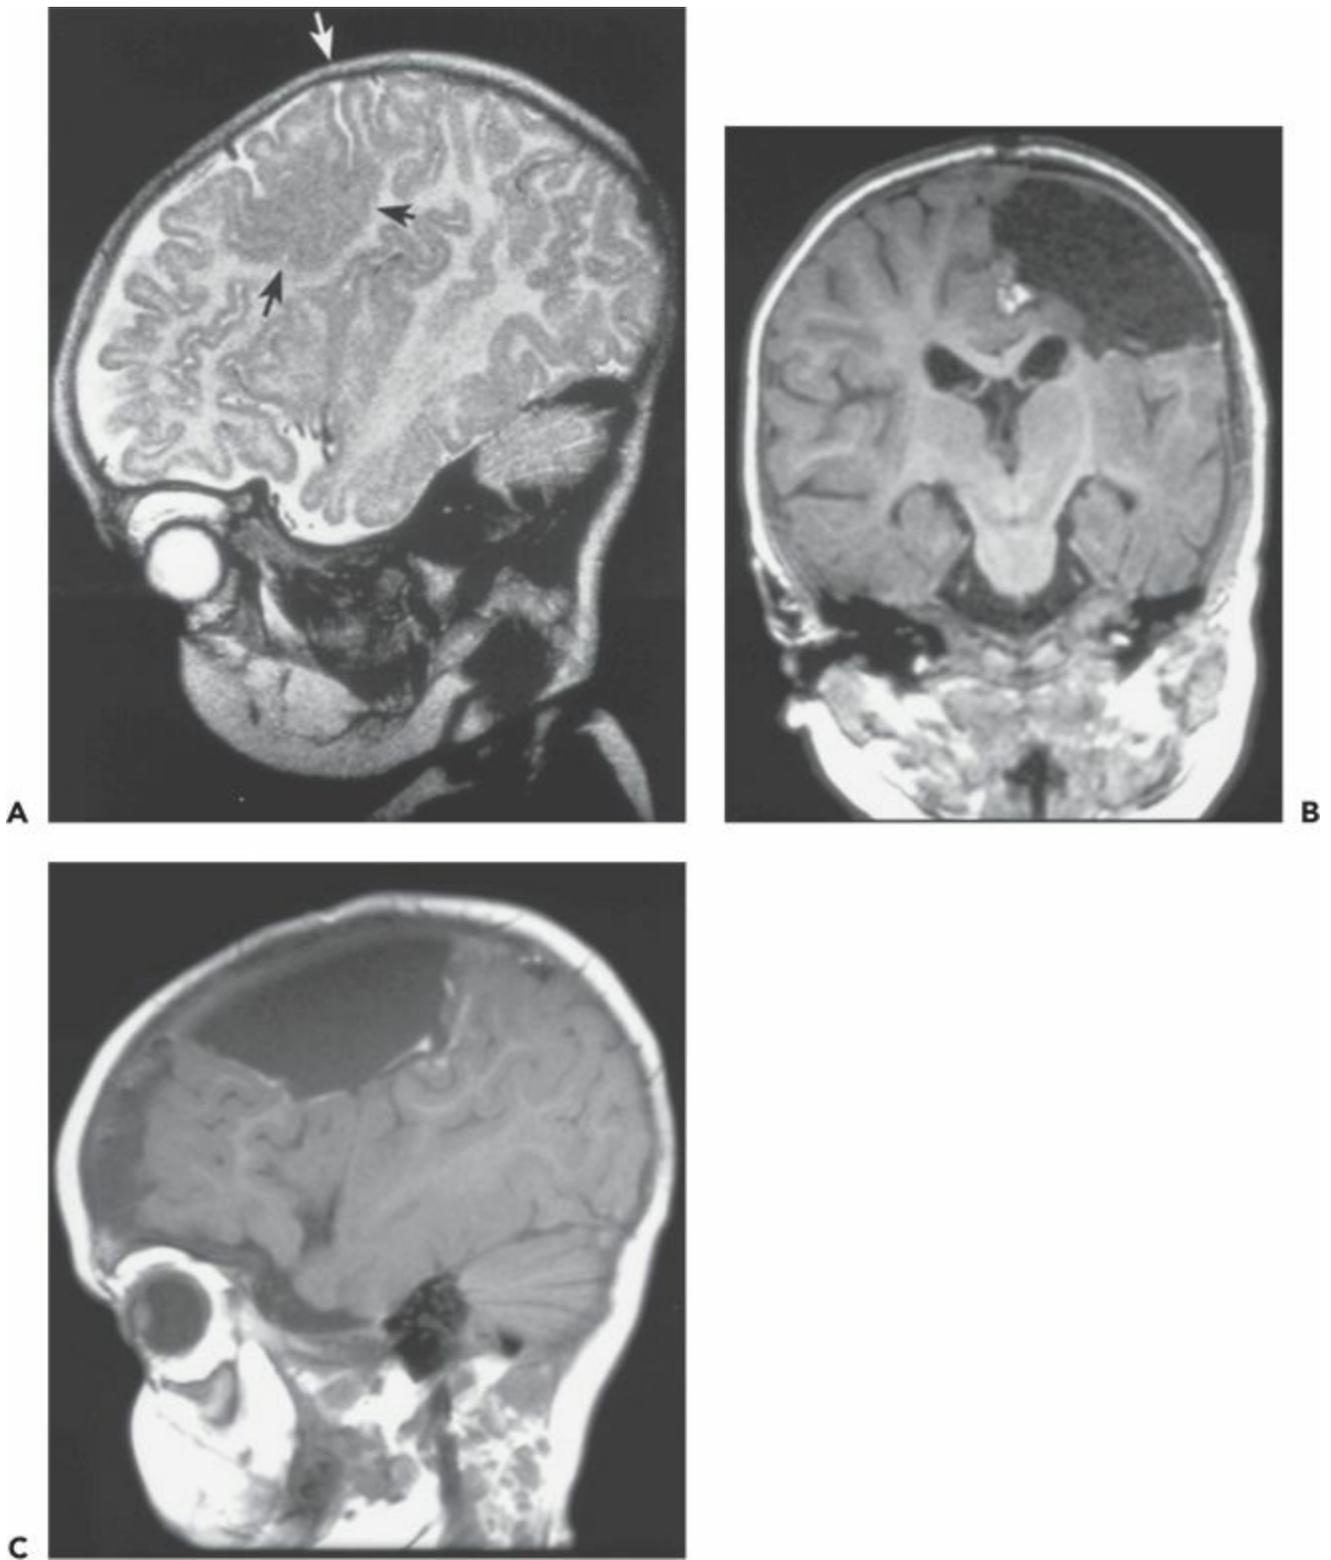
Case 2. A: Sagittal magnetic resonance image showing focal malformation of cortical development cerebral dysgenesis (black arrows) in the left posterior frontal lobe extending across the central sulcus (white arrow) into the anterior portion of the postcentral gyrus. The boy was 4 months old at the time of the MRI, with intractable daily seizures since the first day of life after an uncomplicated full-term delivery. Seizures involved clonic jerking of the right arm and leg, with eye deviation toward the left, or opisthotonic posturing with stiffening and extension of all extremities. Ictal and interictal epileptiform discharges were localized to the left central region. Moderately severe right hemiparesis and mild developmental delay were also present. B: Coronal and (C) sagittal scans performed 2 days after cortical resection at age 9 months. Prior to resection, electroencephalographic seizure was recorded over the lesion with intraoperative electrocorticography, and primary hand motor cortex was identified in the same area by intraoperative cortical stimulation. Postoperatively, the hemiparesis was transiently minimally worse, returning to preoperative baseline within days. Twenty-two months later, the child is making developmental progress and has had no seizures on a reduced dose of antiepileptic medication. (A from Wyllie E. Surgical treatment of epilepsy in children. *Pediatr Neurol.* 1998;19:179–188, with permission.)
